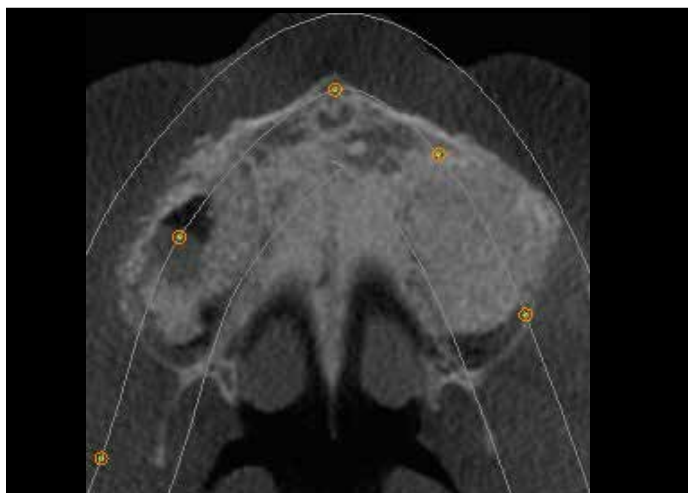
Postsurgical CBCT scan after maxillary sinus augmentation (transverse view) showing radiolucent area in the right sinus where Schneiderian membrane perforation occurred.
